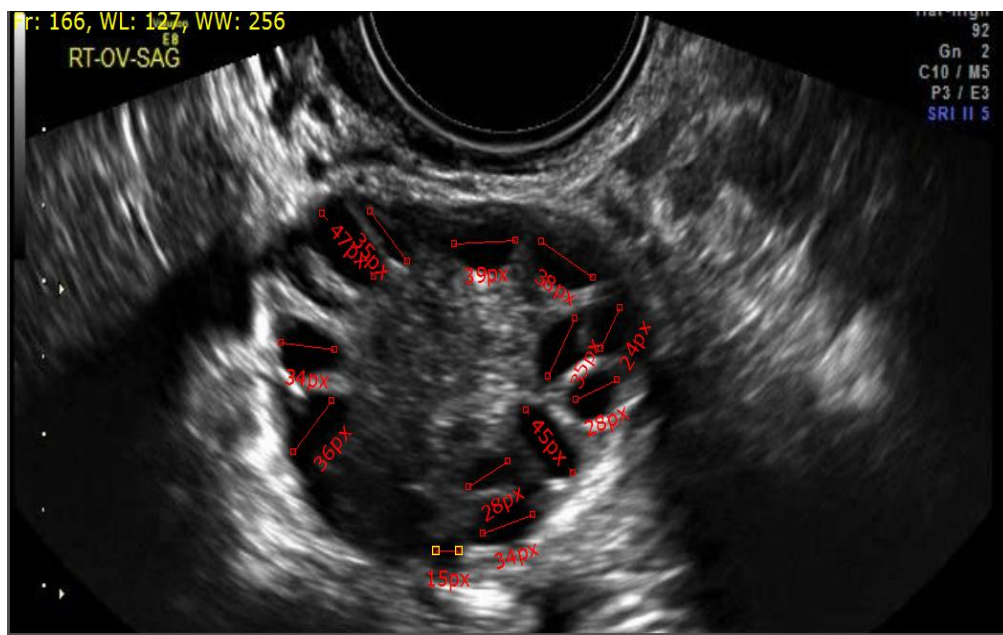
Ultrasound image of a polycystic ovary demonstrating the use of the measuring tool found in Santesoft DICOM editor to measure follicles in their widest planes in pixels.
